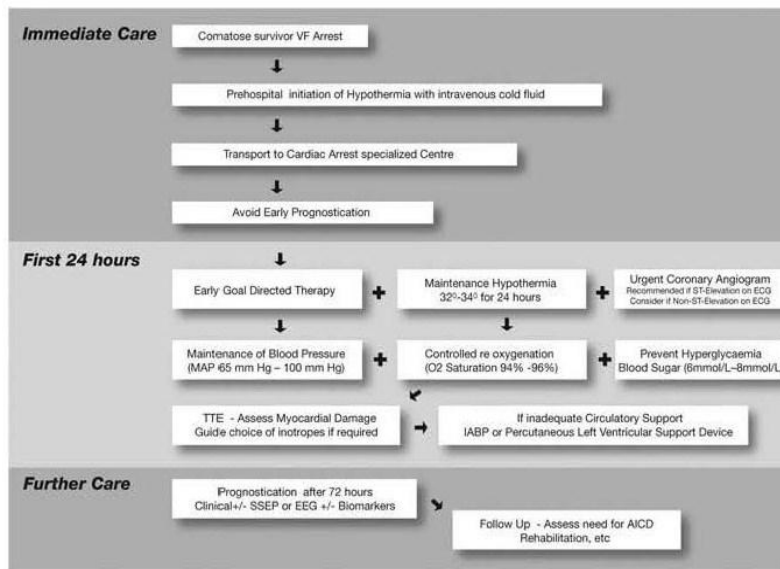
Post cardiac arrest treatment algorithm. MAP indicates mean arterial blood pressure; TTE, transthoracic echocardiogram; IABP, intra-aortic balloon pump; SSEP, somatosensory evoked potentials; EEG, electroencephalography; and AICD, automated internal cardioverter-defibrillator.
